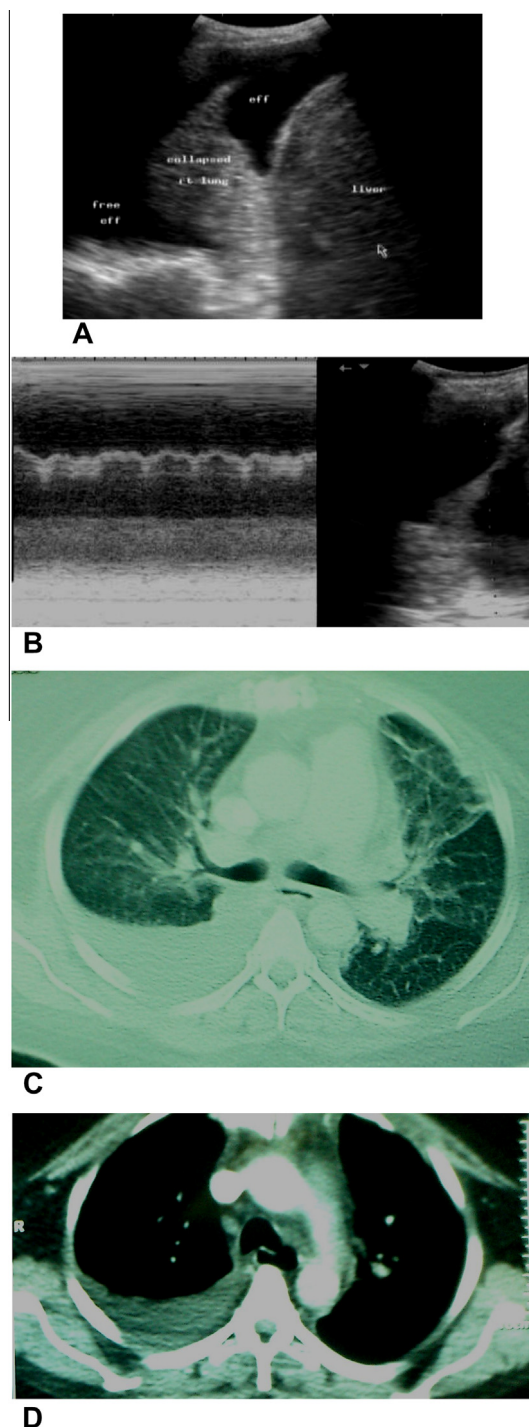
(A) Chest US image in B-mode shows an anechoic right-sided pleural effusion which is abundant enough to be compressive with the atelectatic underlying right lung. The atelectatic underlying right lung is seen as consolidated appearing of liver-like echogenicity and floating in the pleural effusion. (B) Chest US image in M-mode displays the sinusoidal sign which represents the undulating movements of the lung and visceral pleura in the pleural effusion. (C and D) Postcontrast chest CT axial images in lung (C) and mediastinal (D) window settings display right-sided, crescent-shaped, posterior and basal pleural effusion (free effusion) with partial compression collapse of the underlying lower lung lobe.
